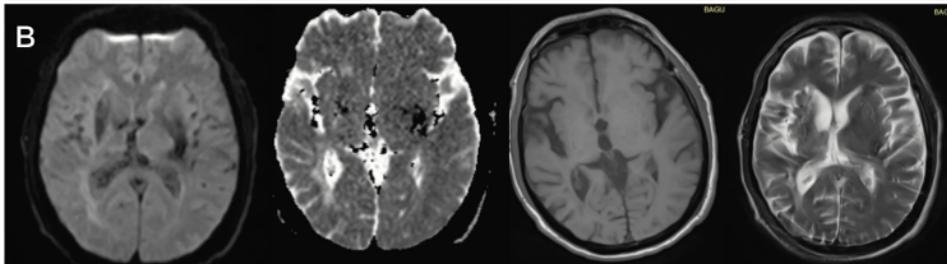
Magnetic Resonance Imaging (MRI) of Cerebrovascular Disease Intracerebral Hemorrhage patients presenting with Hyperkinetic movement Disorder on Day 1 of consult. The following MRI sequences as follows: DWI, ADC, T1 and T2.
